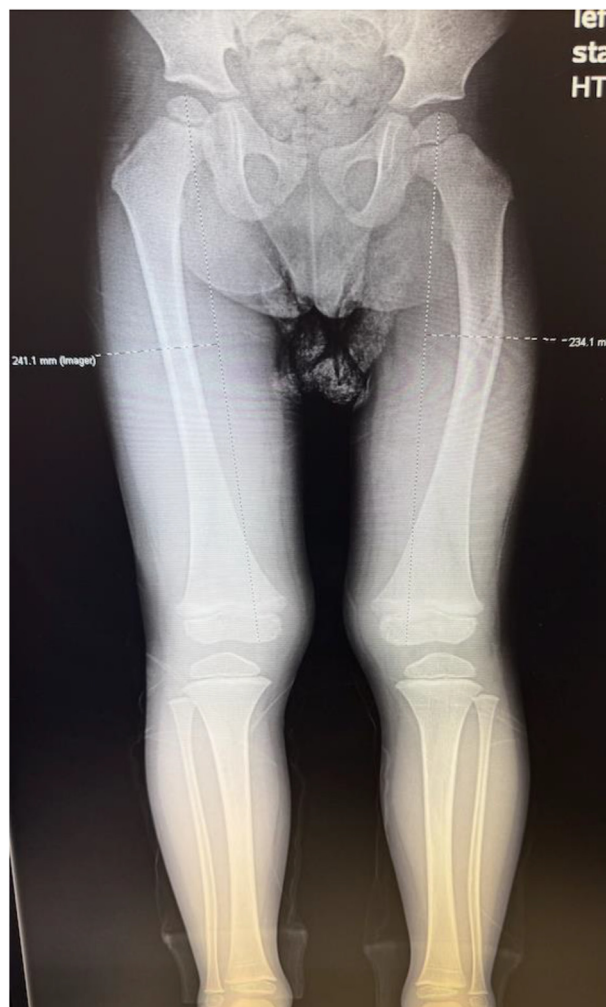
Assessment of limb length discrepancy on standing radiographs.
